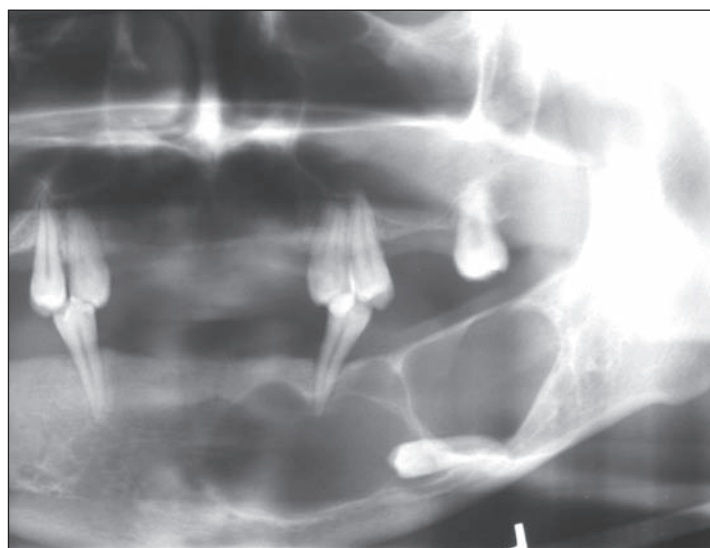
Radiograph of a multilocular odontogenic keratocyst. (Courtesy of Professor C. Nortjé.)
